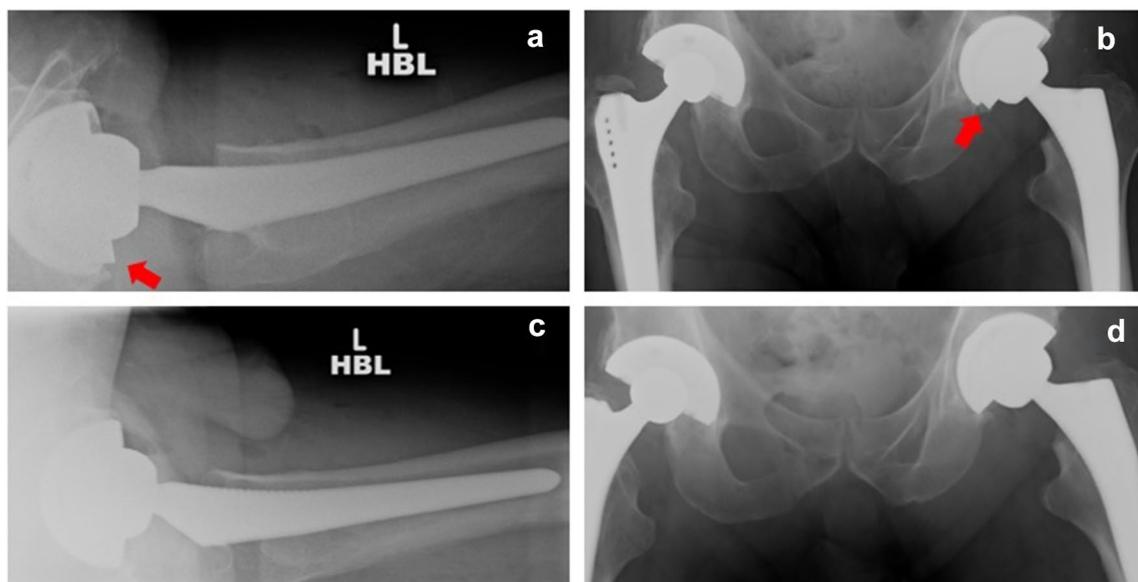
Figure showing lateral (a) and anteroposterior (b) immediate postoperative radiographs for patient 2. Note the malaligned liner (arrows). Lateral (c) and anteroposterior (d) radiographs of the revision surgery showing the acetabular cup in the same position, but the liner is flush to the acetabular cup.
